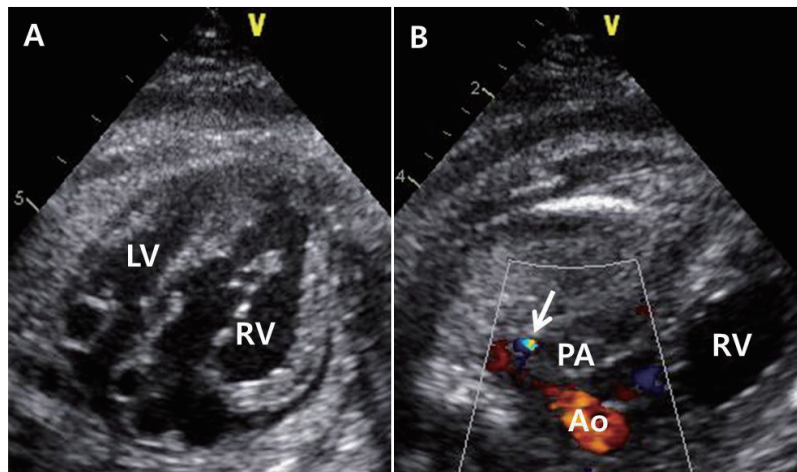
Fetal echocardiogram at gestational age of 37 weeks and 2 days. A: The 2 dimensional image shows a severely enlarged and hypertrophied right ventricle on 4 chamber view. B: Color Doppler reveals prematurely constricted ductus arteriosus with a narrowest diameter of 1.3 mm and length of 6 mm (arrow). RV: right ventricle, LV: left ventricle, PA: pulmonary artery, Ao: aorta.
